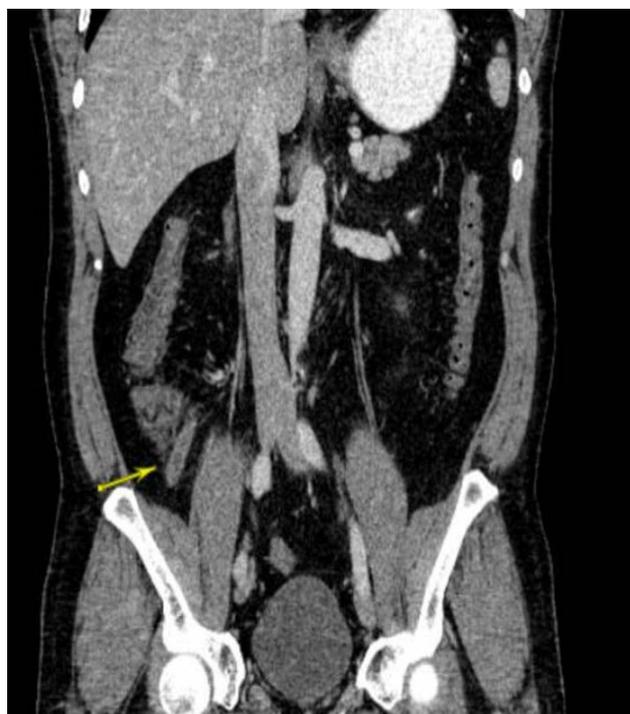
Computed Tomography Scan of the abdomen showing appendiceal thickening suggestive of acute appendicitis
